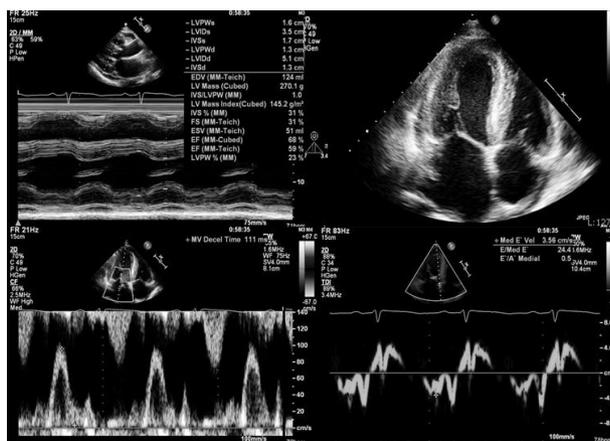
Echocardiography demonstrated increased thickness of the left ventricle (LV) wall and both atrial enlargement and normal systolic function with normal wall motion. Mitral inflow and mitral annular Doppler tissue velocities showed grade 3 diastolic dysfunction and high E/E', suggesting markedly elevated LV filling pressure.
